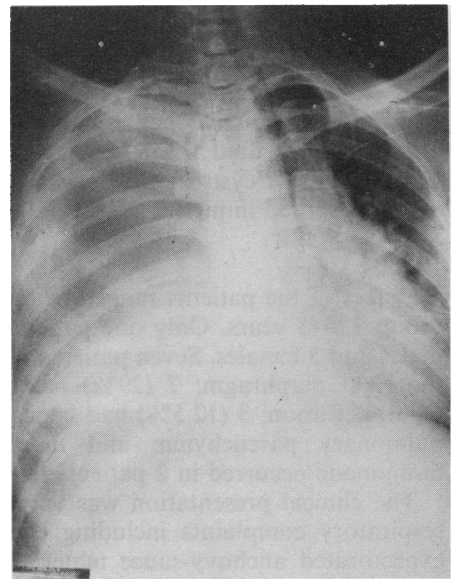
Posteroanterior chest X-ray showing amoebic pleural empyema in continuity with fluid space under right hemidiaphragm
